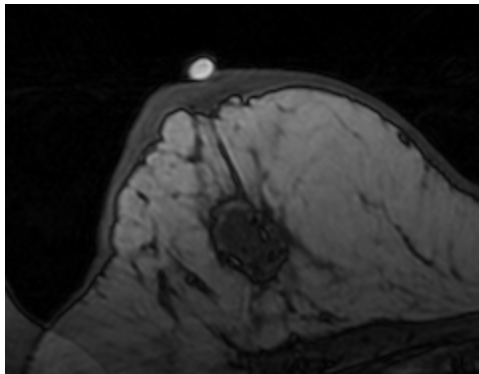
Transaxial view from the MRI image of the patient's breast showing fiducial marker located at nipple.
